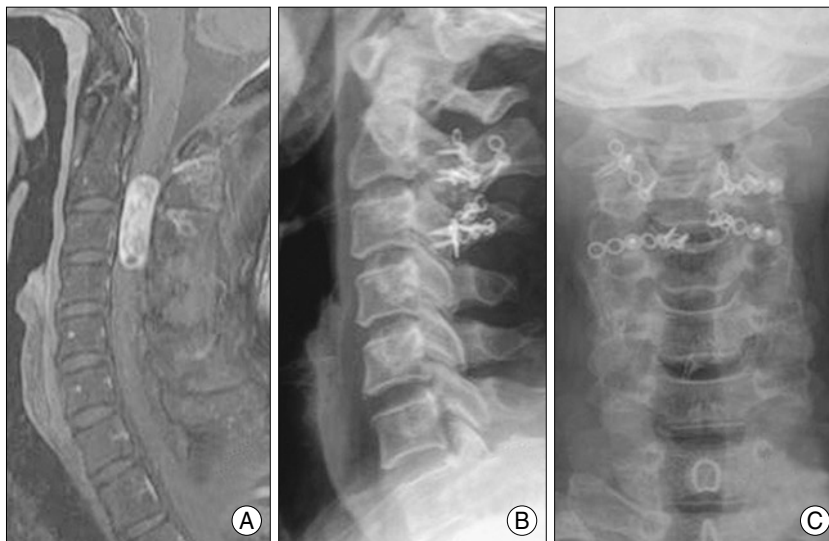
A 50 year-old man with intradural extramedullary tumor on C2-3 level before and after removal of tumor and laminoplasty. A : Preoperative magnetic resonance imaging shows intradural extramedullary mass-like lesion on C2-3 level. B, C : Postoperative X-rays show laminoplasty state.
